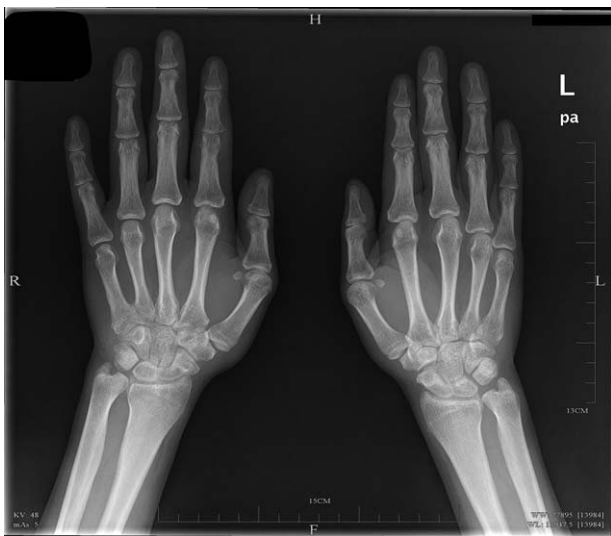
Preoperative radiographs showing a bone cystic defect in his proximal interphalangeal joint of right index finger.
